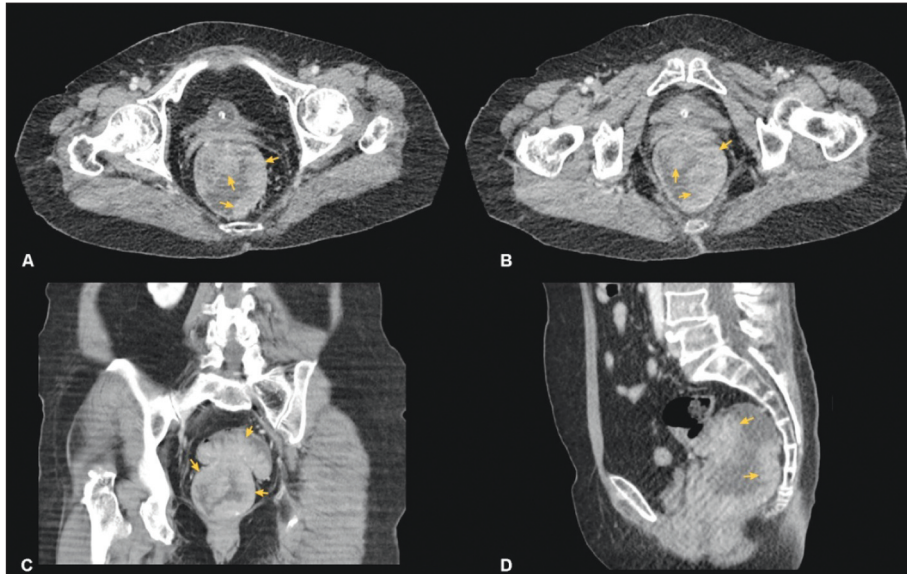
Axial (A, B), coronal (C), and sagittal (D) plan intravenous contrast-enhanced computed tomography images show an intraluminal polypoid lesion (arrows) with soft tissue density resulting in expansion of the rectum, beginning about 2 cm distal from the anal canal entry and spreading along the rectum.
